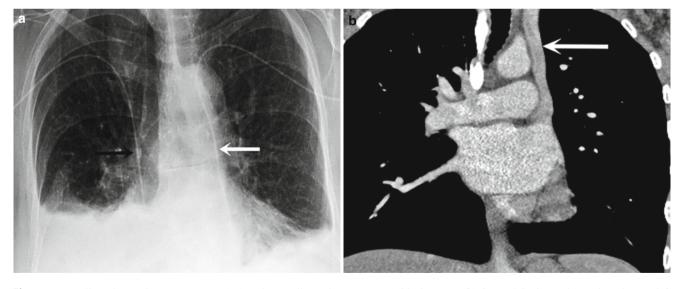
Duplicated superior vena cava. (a) AP chest radiograph shows two peripherally inserted central catheters (PICCs), one in the left superior vena cava (*white arrow*) and the other in the right superior
